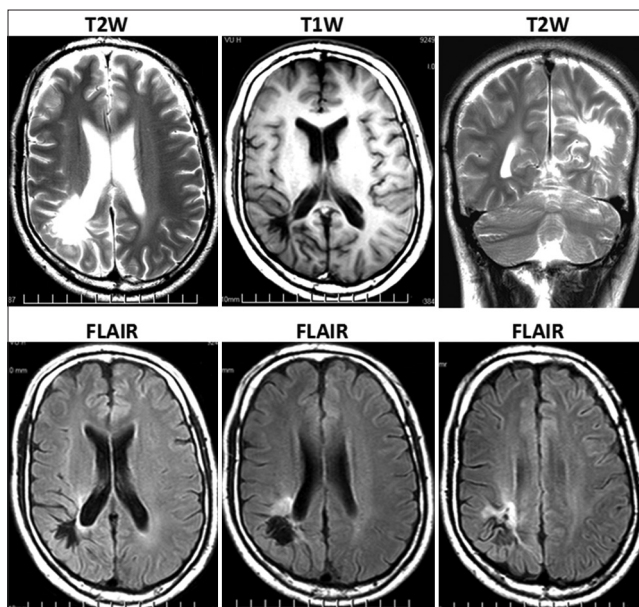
Conventional magnetic resonance images of a 36-year-old male patient. T2W, T1W, fluid-attenuated inversion recovery (FLAIR) axial, and T2W coronal images showing a star-shaped neurological scar in the right temporo-occipital region, which contained fluid (hyperintense on T2W images, hypointense on T1W and FLAIR images), had wrinkled edges, and exhibited a size of $1.8 \times 2.4 \times 2.0$ cm; this scar was located very close to the occipital horn of the right ventricle
